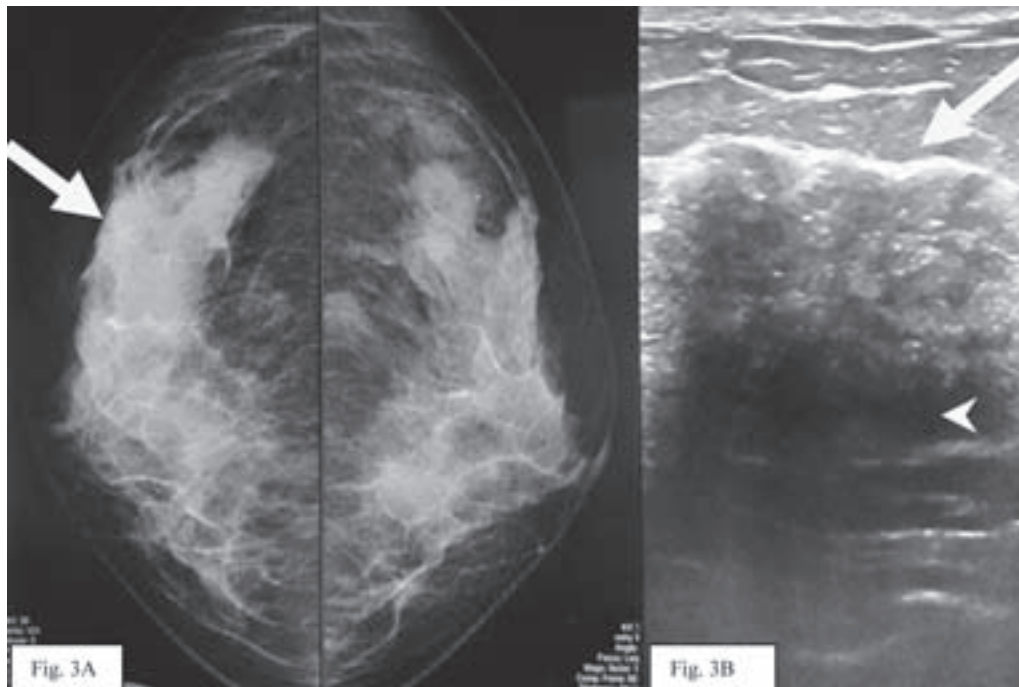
A 53 years old woman with diabetes mellitus presented with a palpable right breast mass with mammographic and ultrasonographic features mimicking malignancy. Mammogram (Figure 3A) showed asymmetrical breast tissue with dense area over mid-lateral region of right breast (arrow). Ultrasonogram (Figure 3B) demonstrated ill-defined hypoechoic mass-like appearance (arrow) with strong posterior shadowing (arrow head). Malignancy was suspected with the diagnosis of BI-RADS 5. Pathology turned out to be chronic mastitis, compatible with diabetic fibrous mastopathy.
